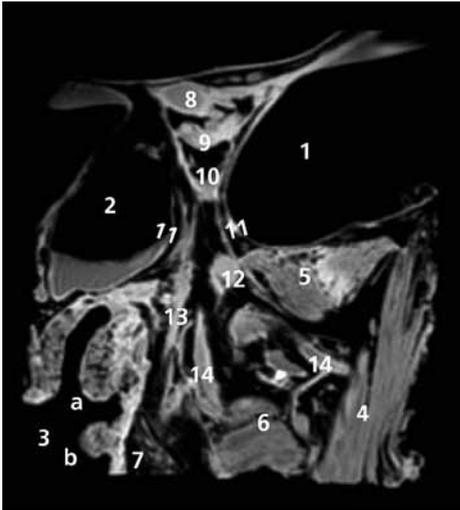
Coronal MR image of left PPF
